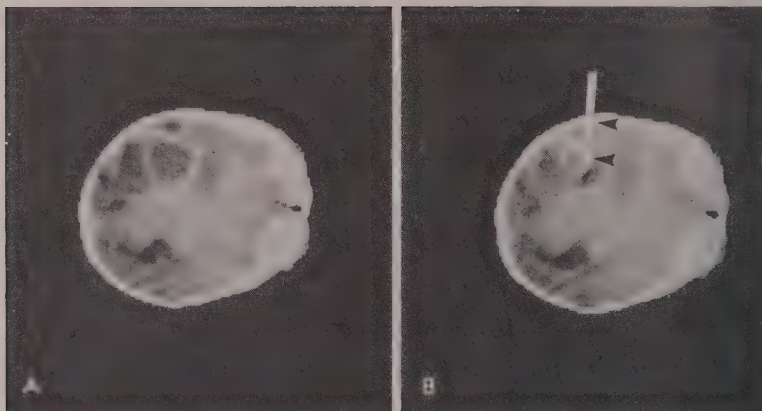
CT-guided aspiration of multilocular abscesses in a 4 year old boy. CECT scans. A. Prior to aspiration, CECT reveals three loculated abscesses, surrounding edema and obliteration of the left lateral ventricle. B. Intra-procedural CECT shows the aspiration needle (arrowheads) positioned within the deepest of the collections. The course of the needle outside the abscess reproduced poorly and is therefore indicated by a white line.
